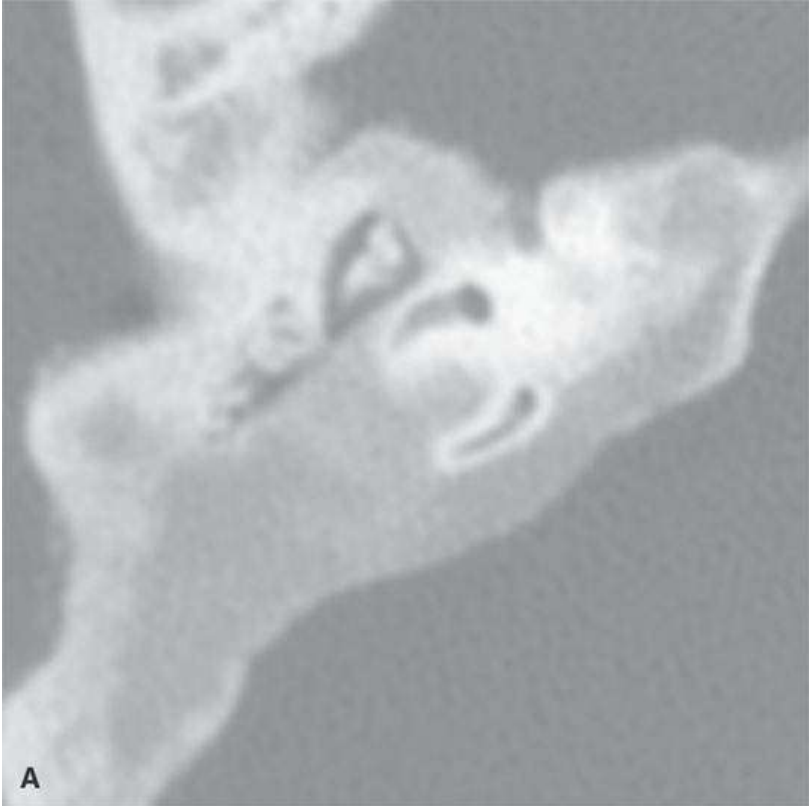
The fibro-osseous variations of fibrous dysplasia. A–C: Computed tomography of fibrous dysplasia in three different patients.
